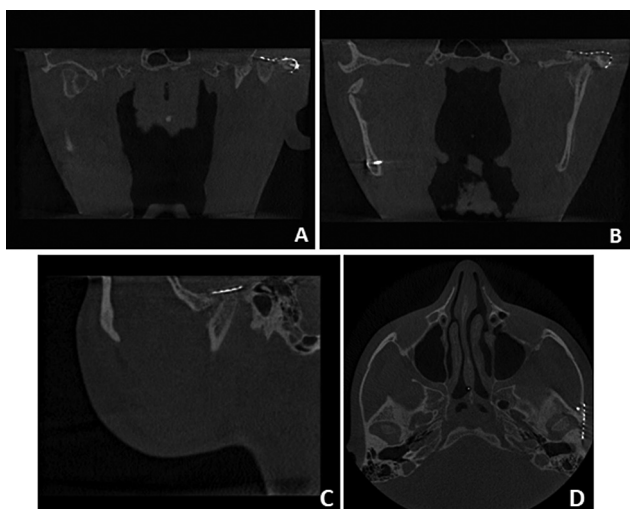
Computed tomography (CT) at 60 days of follow-up. (A, B) Coronal, (C) sagittal, and (D) axial views demonstrating titanium mesh in position with absence of foci of pneumocephalus.
